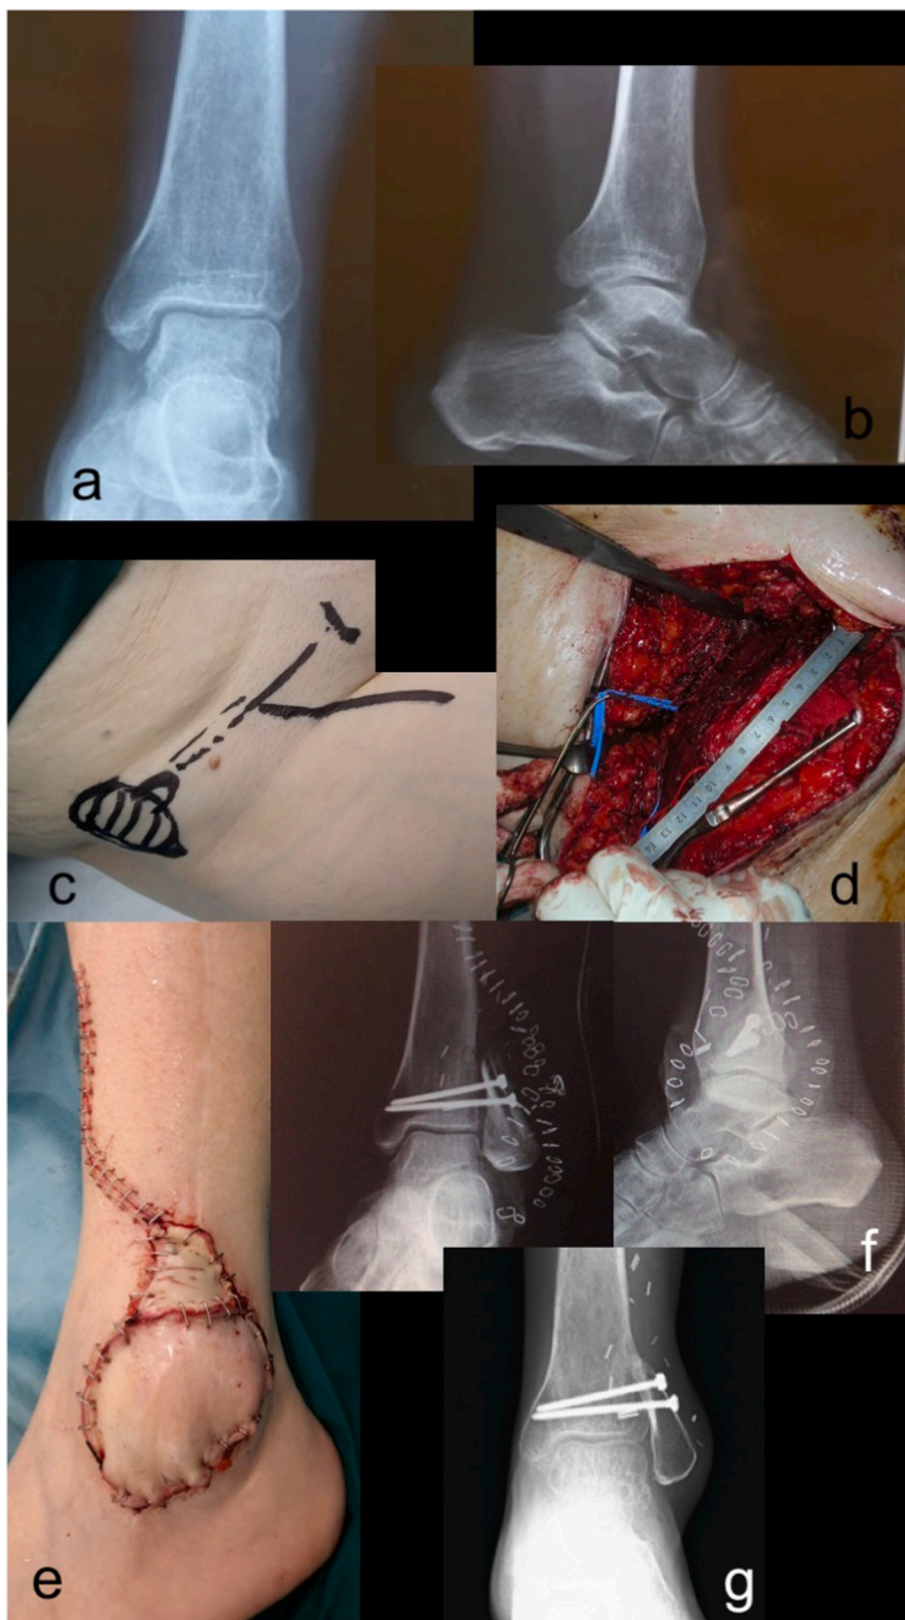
Clinical and radiographical appearance of patient 3. a and b) Preoperative radiographic assessment, b and c) Flap design and dissection including the skin paddle, d) Final appearance at the end of surgery, e) Postoperative x ray, f) Five-year radiographic follow-up.
